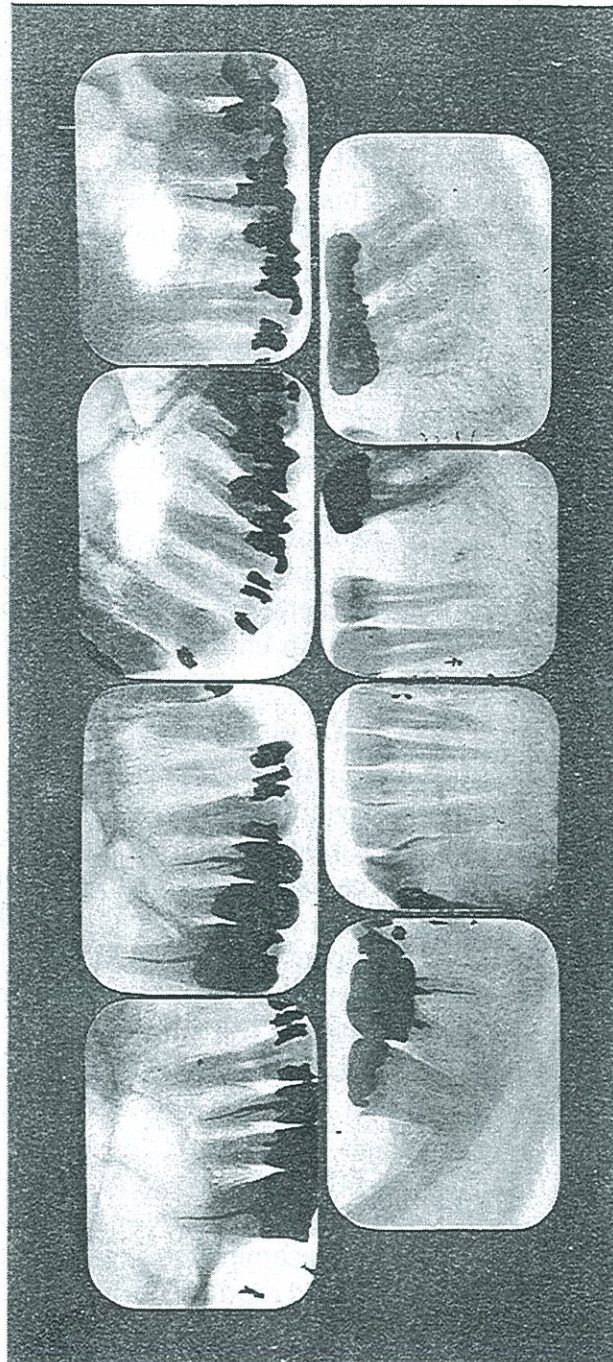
ROENTGENOGRAPHIC APPEARANCE OF TEETH, CASE 1241 WITH ANGINA PECTORIS. PATIENT APPARENTLY IMPROVED.
